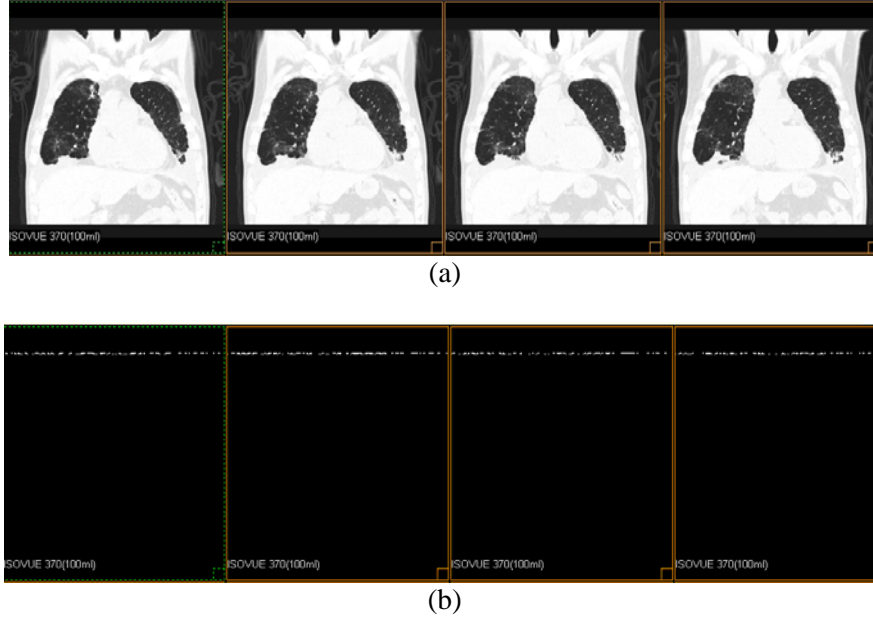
Example of the 3-D LDSERS results of a reformatted CT Coronal Chest Volume. The images are reformatted and displayed from anterior to posterior. (a) Four consecutive images of the CT volume with a partial digital signature embedded; (b) The subtracted images between the four original CT images and (a) showing where the digital signature is embedded.
